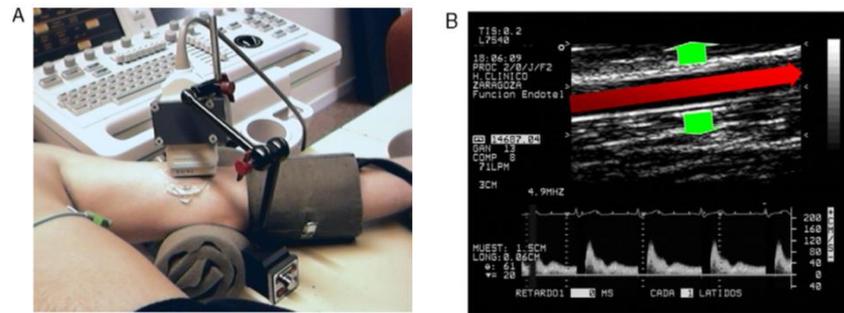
(A) Setting for flow-mediated dilation testing. The picture showing the ultrasound probe in a fixed position in the upper arm, and the blood pressure cuff on the lower forearm used to occlude blood flow. (B) Ultrasound image of brachial artery used to measure both the diameter changes and flow velocity. The red arrow shows the direction of blood flow through the vessel and the green arrows show the diameter which is the measurement taken before and after occlusion. Taken from Arrebola-Moreno *et al.*, (2012).
